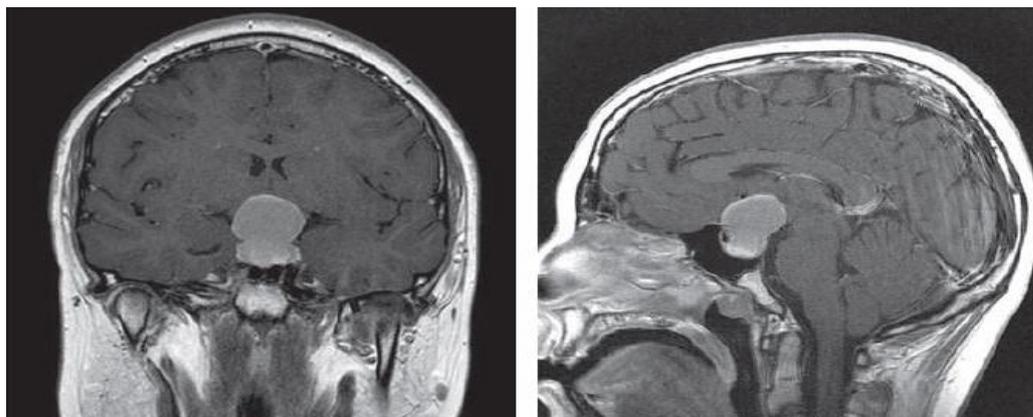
14-Year-Old Girl with Bitemporal Hemianopsia and Obesity. After an MRI examination, a suprasellar craniopharyngioma growing within the sella turcica was diagnosed.
